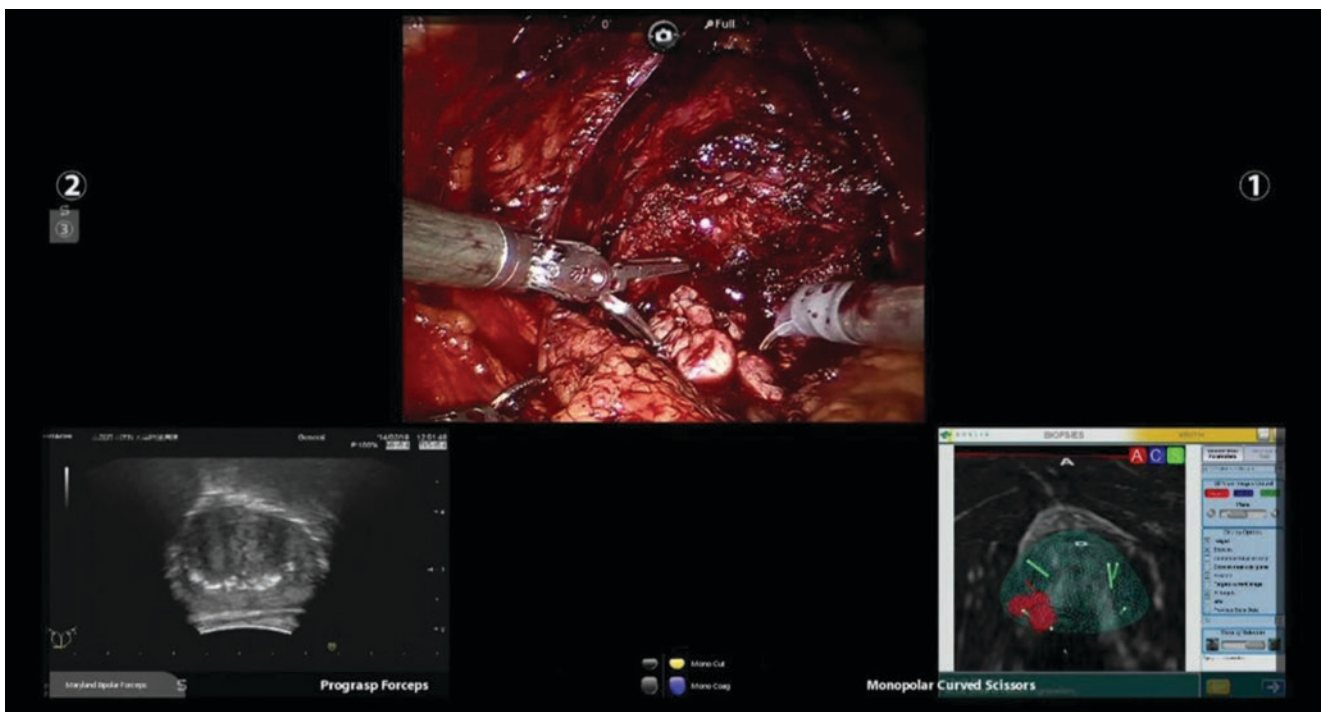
Intraoperative transrectal ultrasound (TRUS) images of a prostate in RARP
